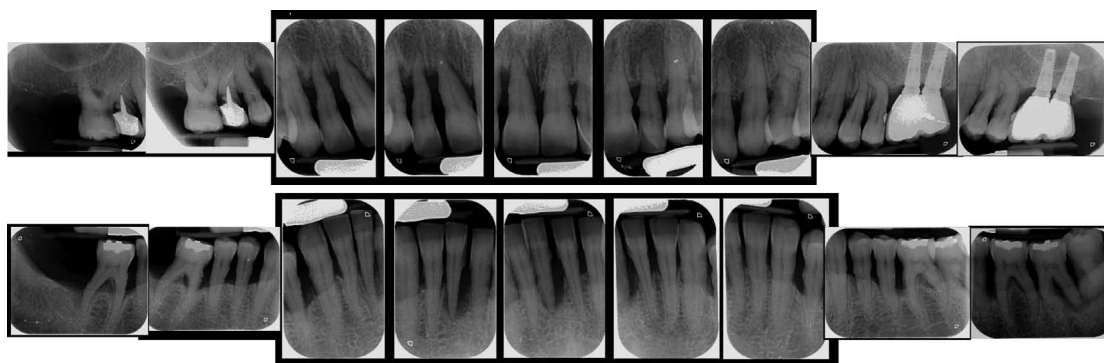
Radiographic diagnosis of periodontitis.
